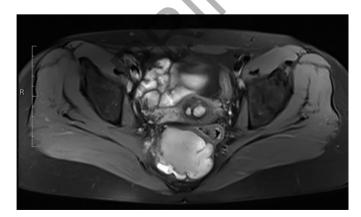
Preoperative MRI scan (T1).
